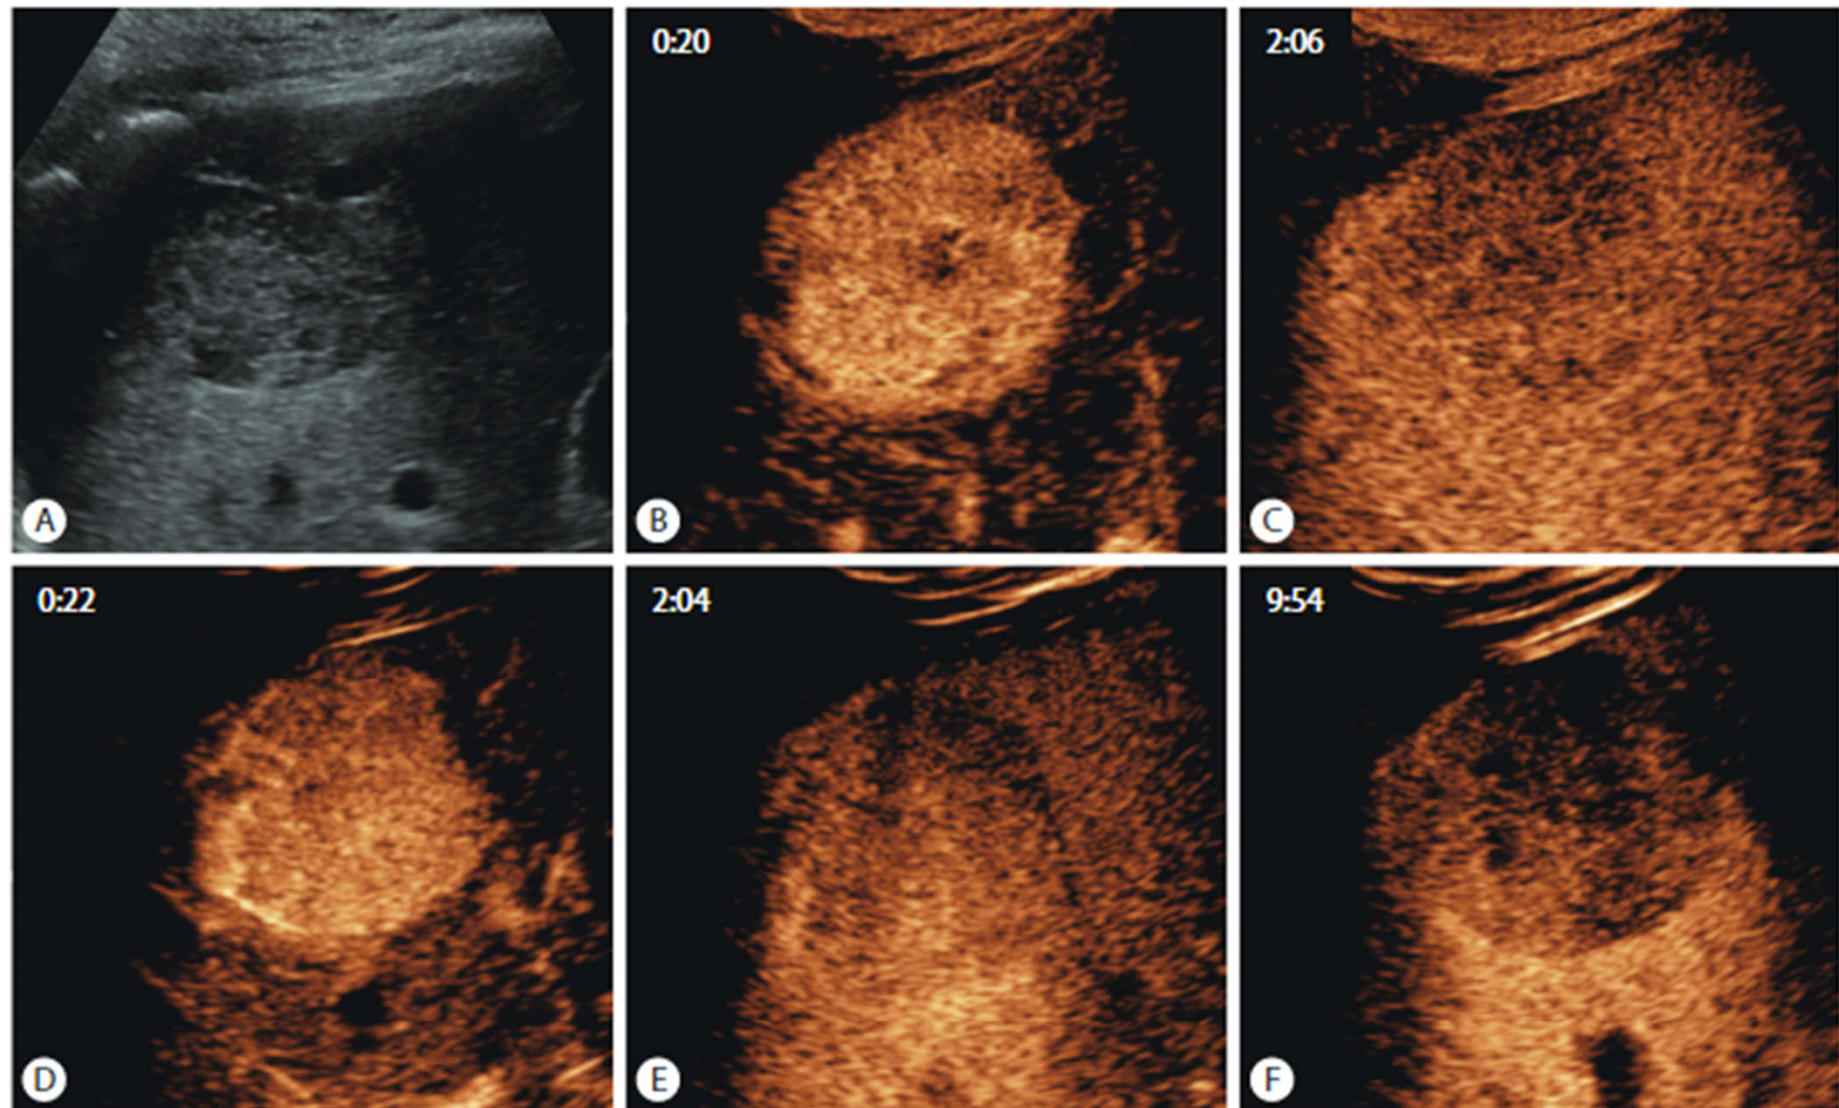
Typical contrast-enhanced ultrasound findings of hepatocellular carcinoma using SonoVue and Sonazoid. (A) Approximately 4.5-cm sized hypoechoic mass in liver segment 6 on B-mode ultrasound. After administration of SonoVue, the mass shows (B) hyperenhancement in the arterial phase (20 seconds) and (C) mild washout in the delayed phase, but not devoid of enhancement (126 seconds). The same lesion enhanced with Sonazoid also shows (D) arterial phase hyperenhancement (22 seconds) and (E) mild delayed washout (124 seconds), as well as (F) clear hypointensity in the Kupffer phase (approximately 10 minutes after contrast administration).
